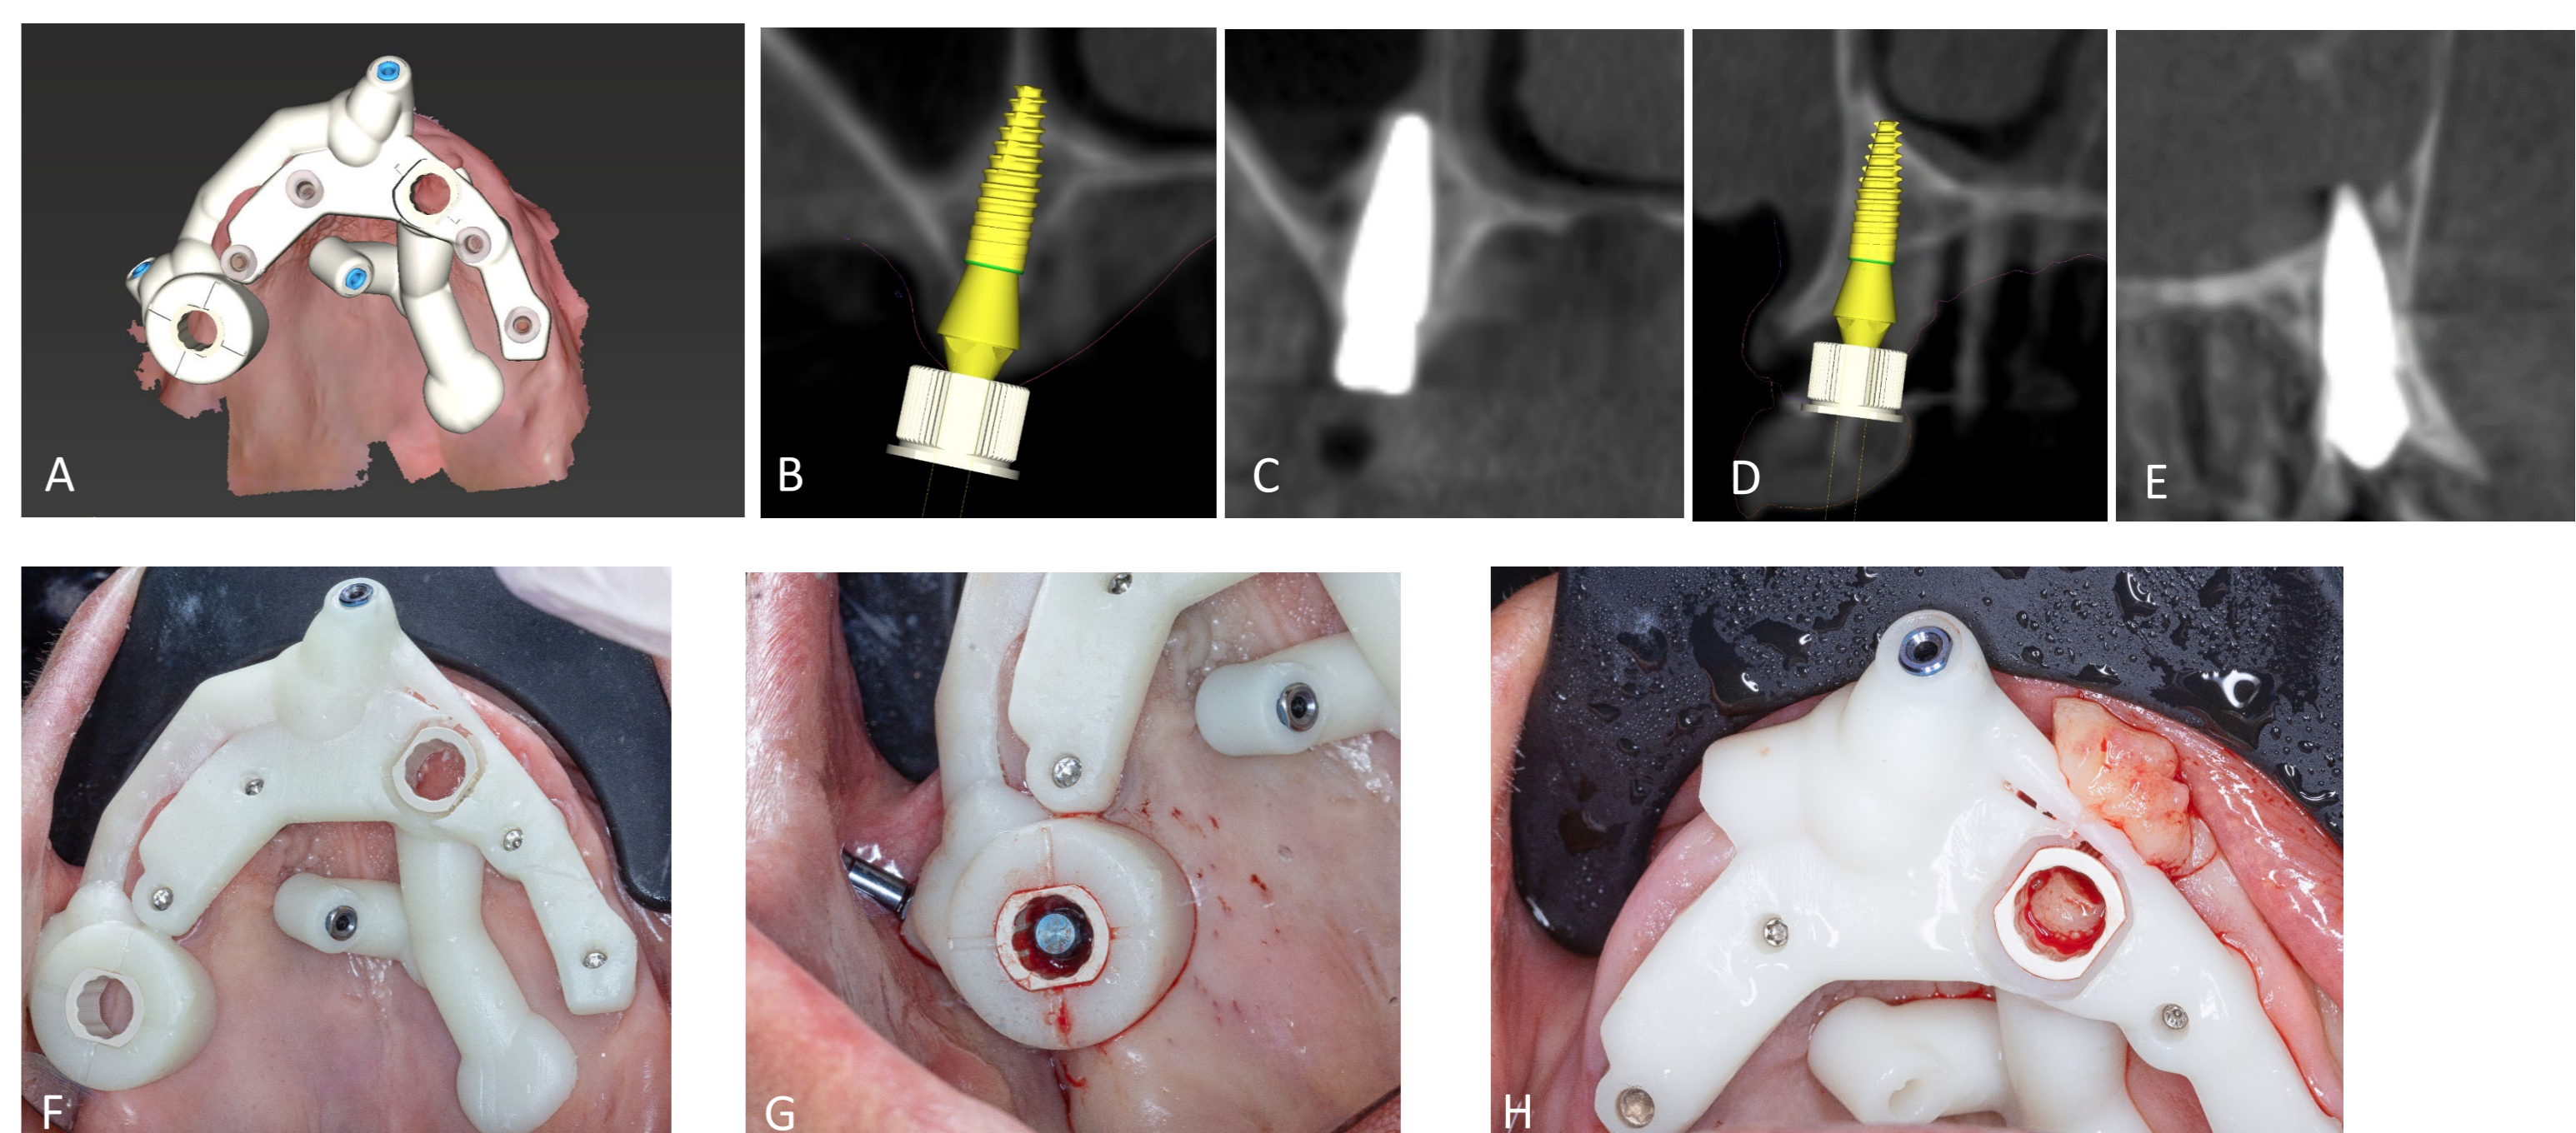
A) Screw retained surgical guide, B) Virtual implant planning, C) CBCT after placement, D) Virtual implant planning, E) CBCT after placement, F) surgical-guide design fixed in place, G) implant placement fully-guided, H) Detail of flap management for fully-guided implant placement
